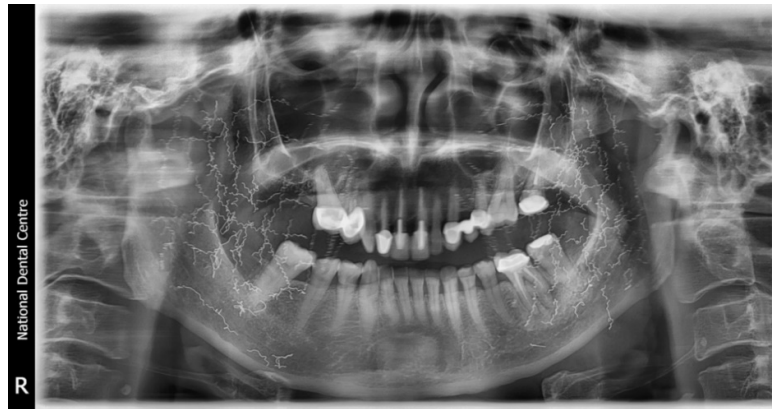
Panoramic radiograph showing multiple, filamentous, springy radio-opacities of varying lengths, criss-crossing haphazardly; observed bilaterally in the region of the mandibular rami and posterior teeth
